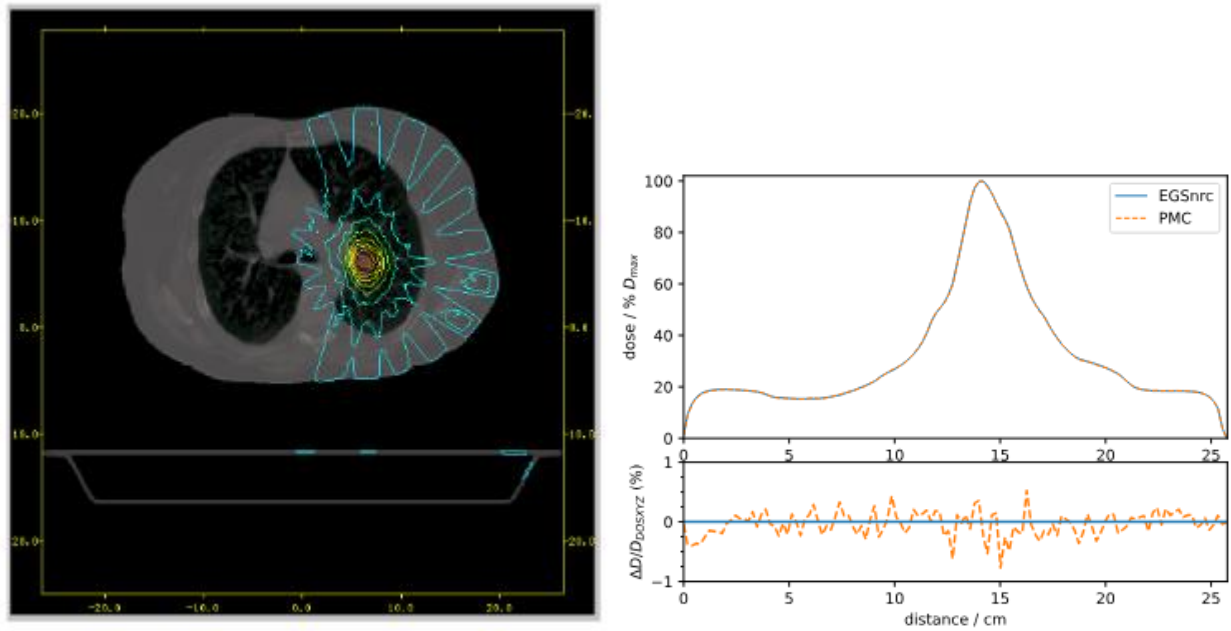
Validation of PMC accuracy for an SBRT plan in a heterogeneous lung patient. Axial CT slice as displayed using dosxyz_show. (Left) Vertical dose profile through one of the static fields. (Right)
